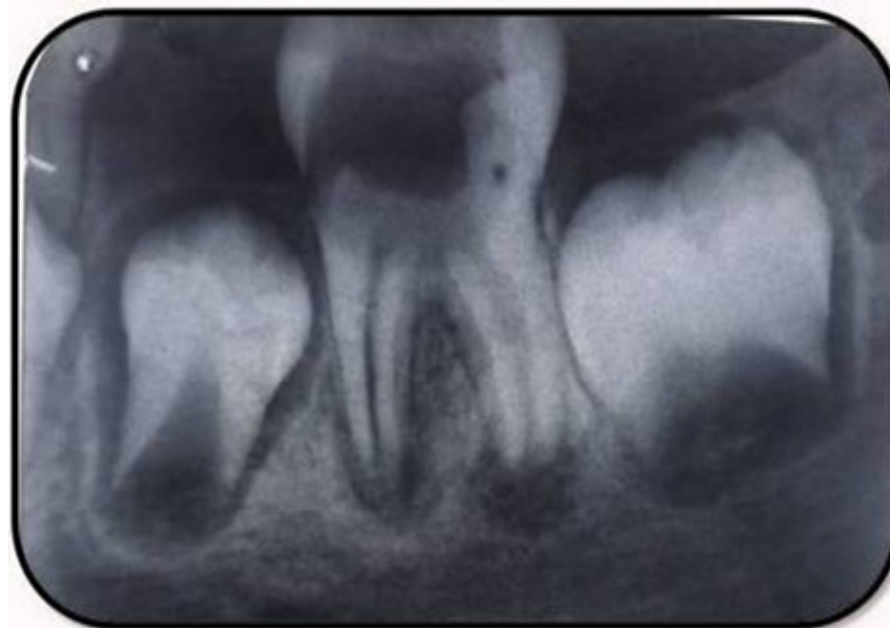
IOPA radiograph showing pulp, furcation and periapical involvement
